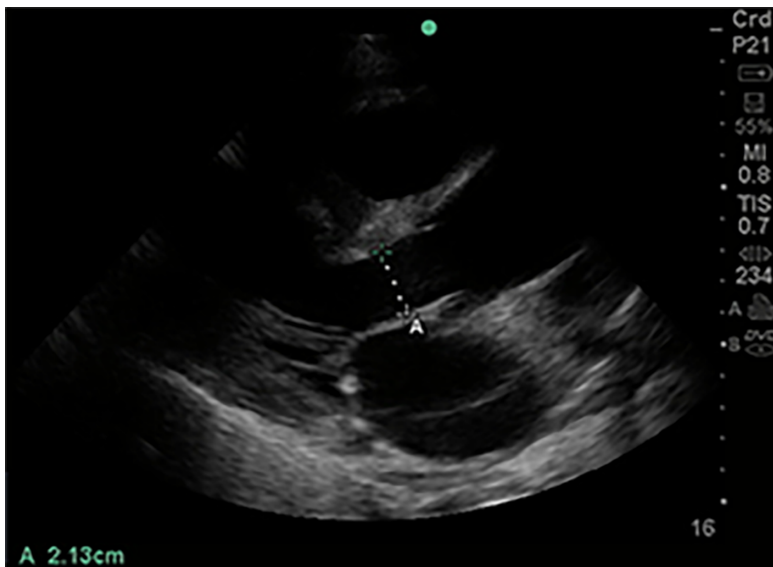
Left ventricular outflow tract diameter parasternal long axis view. Of 1-5 MHz phased array probe with probe marker facing patient's right shoulder, parasternal long axis view. Left ventricular outflow tract diameter measured during mid-systole, inner edge to inner edge, from septal endocardium to anterior mitral leaflet, in order to calculate cross-sectional area (πr^2).
